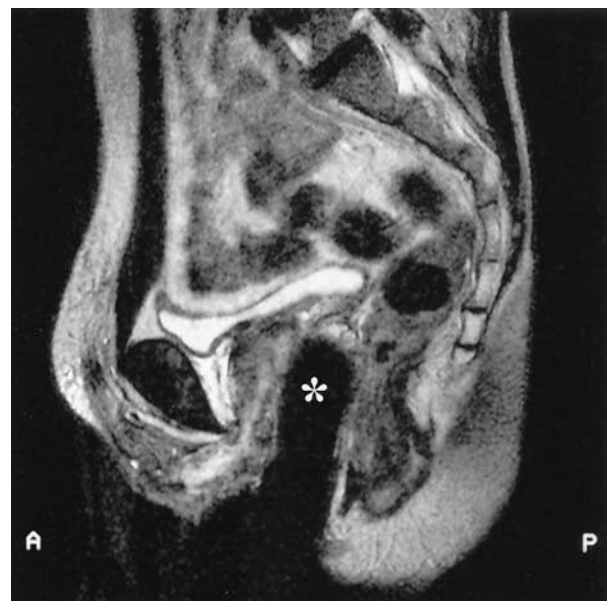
Sagittal turbo spin-echo T2-weighted image. An inflatable silicon tutor is located in the neovagina (*), which shows a correct inclination from front to rear and from low to high.
